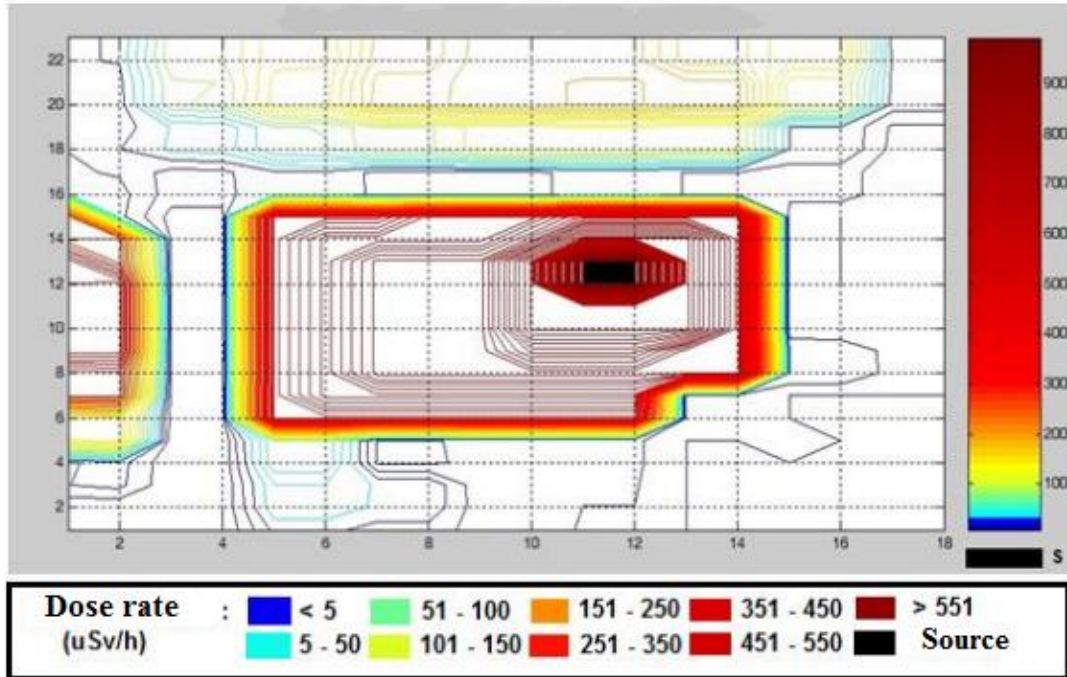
The distribution of radiation in the CT Scan Multi-Slice 64 room at Sanglah Hospital
